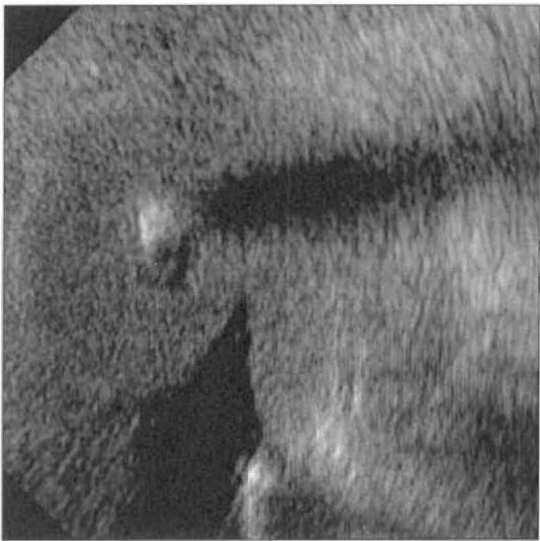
Ultrasound image of female genital tract.
